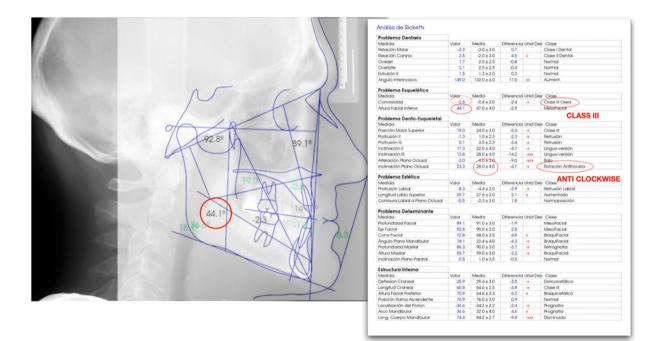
Initial tele-radiography with Ricketts cephalometric analysis.
